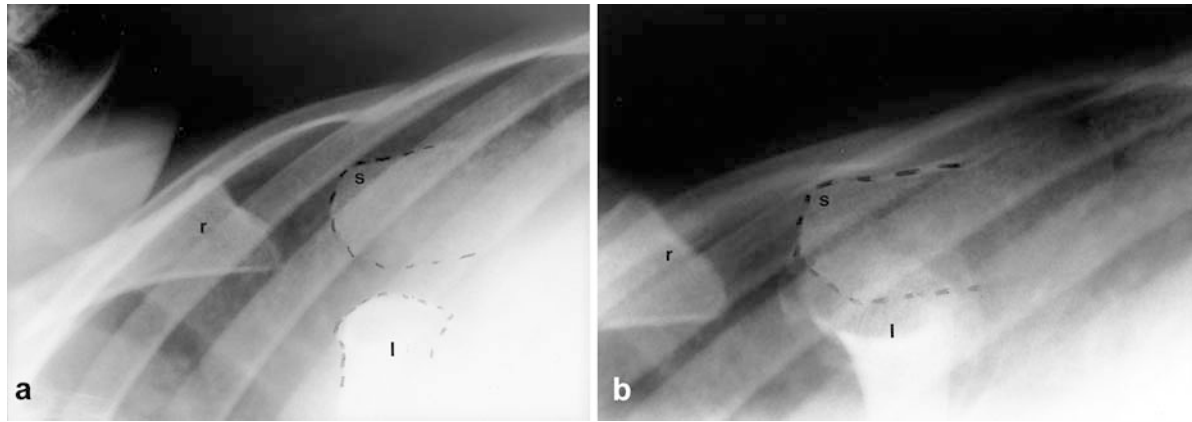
Left posterior sternoclavicular dislocation. Right to left cross-table lateral X-ray ("Heinig projection") with left arm alongside chest demonstrates retrosternal dislocation of left clavicle (l) before (a) and normal sternoclavicular superposition after (b) reduction. Sternum (s); right clavicle (r) with ipsilateral arm elevated. (A.E., 8-year-old boy)
